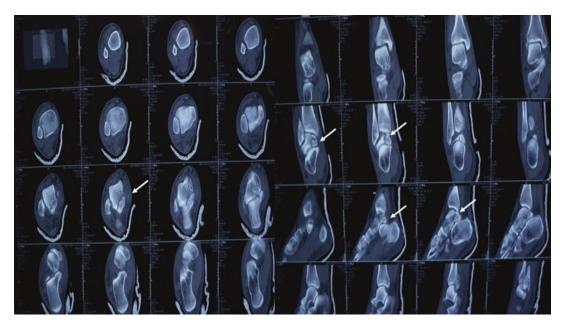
Sections of CT scan in sagittal, coronal, and transverse plane after closed reduction. Arrows show fracture line
